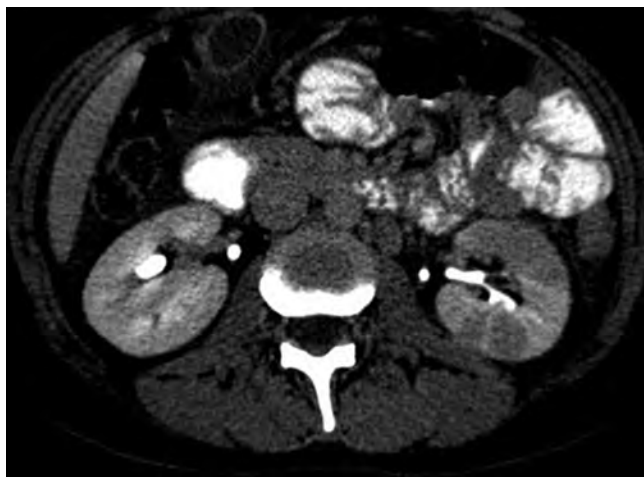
Computed tomography scan demonstrating lobar nephronia.
